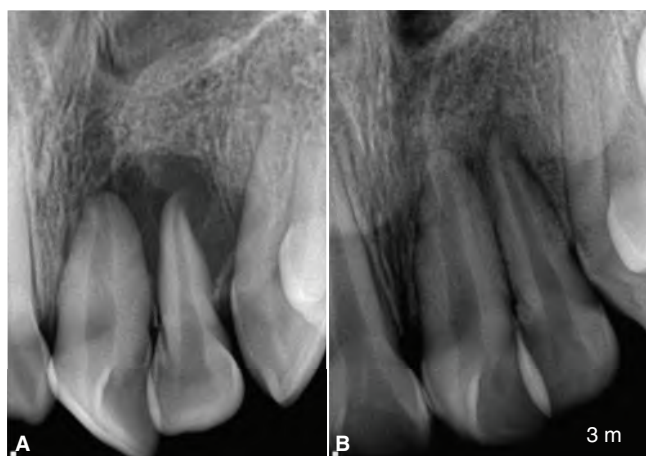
A. Periapical radiograph showing an apical radiolucency in a 12-year-old boy. Patient complained of pain and reported a history of trauma to the anterior maxilla. The associated apical radiolucency is most likely consistent with a *traumatic bone cavity* but could represent other conditions such as radicular cyst, periapical granuloma, or an odontogenic tumor (based on radiographic features alone without biopsy) All anterior teeth tested normal to pulp sensibility tests as compared to unaffected control teeth. B. Periapical radiograph, taken 3 months after initial presentation, showing bone-fill in the region following conservative treatment with antibiotics and close monitoring. The patient was asymptomatic within 2 weeks. On 1-year recall, the area remained healthy. (Courtesy of Dr. Diego Dalla-Bona, Los Angeles, CA.)
